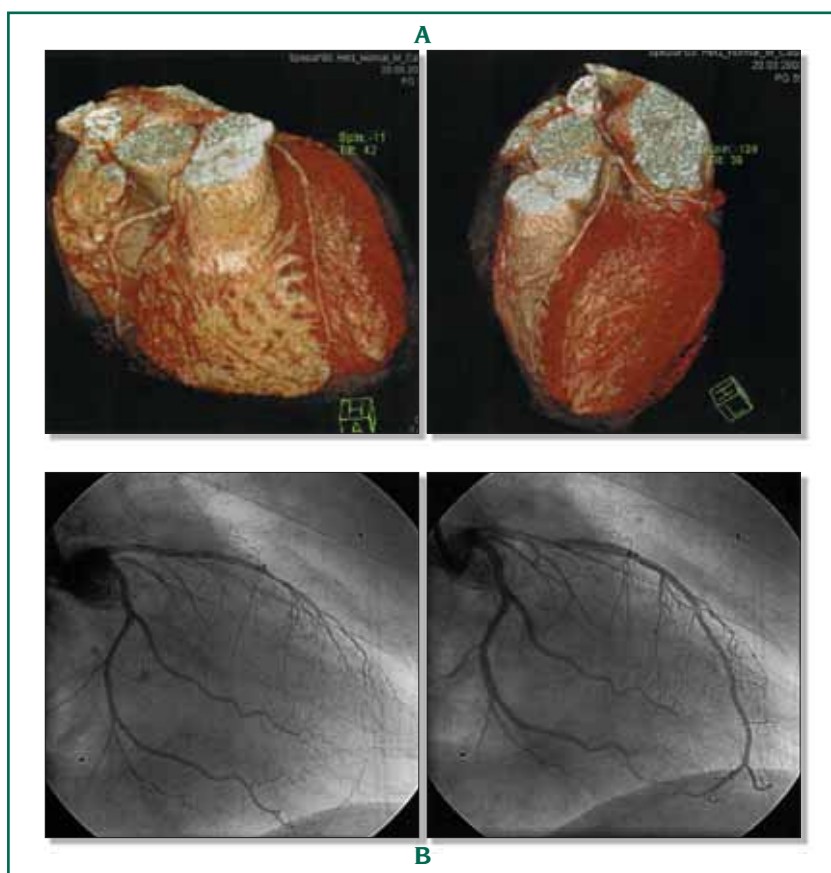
A: Exclusion of significant coronary stenoses by 3-D MSCT reconstruction: 16-slice multi-slice computed tomography (MSCT) 3-dimensional reconstruction of coronary arteries of a patient with repetitive attacks of resting angina. Exercise tests were repeatedly normal. The CT does not show significant coronary artery disease. B: Left anterior descending (LAD) coronary artery vasospasm. Left: when 100 μ g acetylcholine is selectively infused into the LAD, the patient experienced identical symptoms as those that brought him into the hospital, and subtotal occlusion of the distal LAD was observed. Right: After injection of 0.2 mg nitroglycerin (NTG), the vessel opened wide and the symptoms disappeared immediately.
